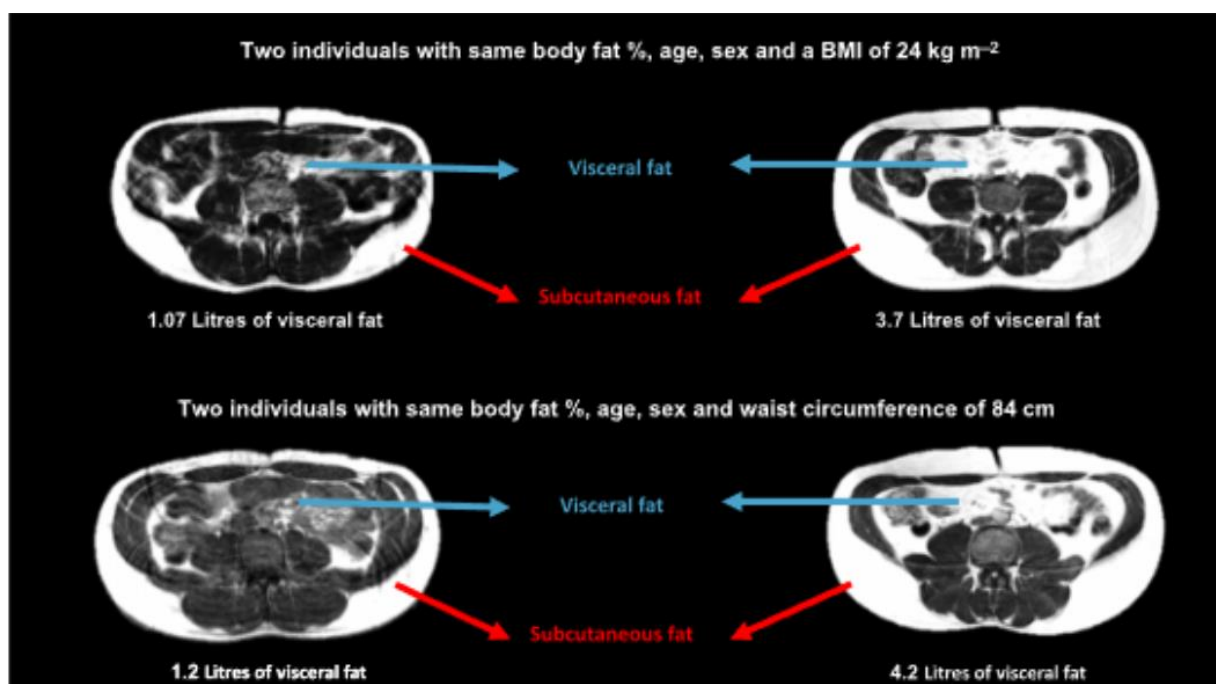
Demonstration of diverging levels of fat tissue via transverse slices of an abdominal MRI of two people with same BMI or WC, age and gender by Yaghootkar et al. 2020
